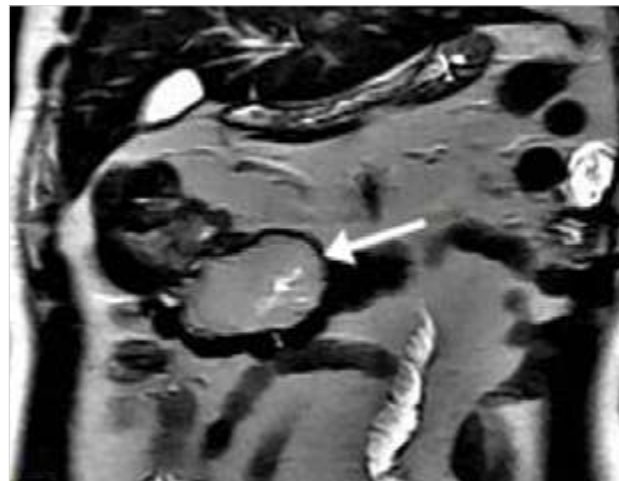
Magnetic resonance imaging view of the lesion, arrow pointing the mass
